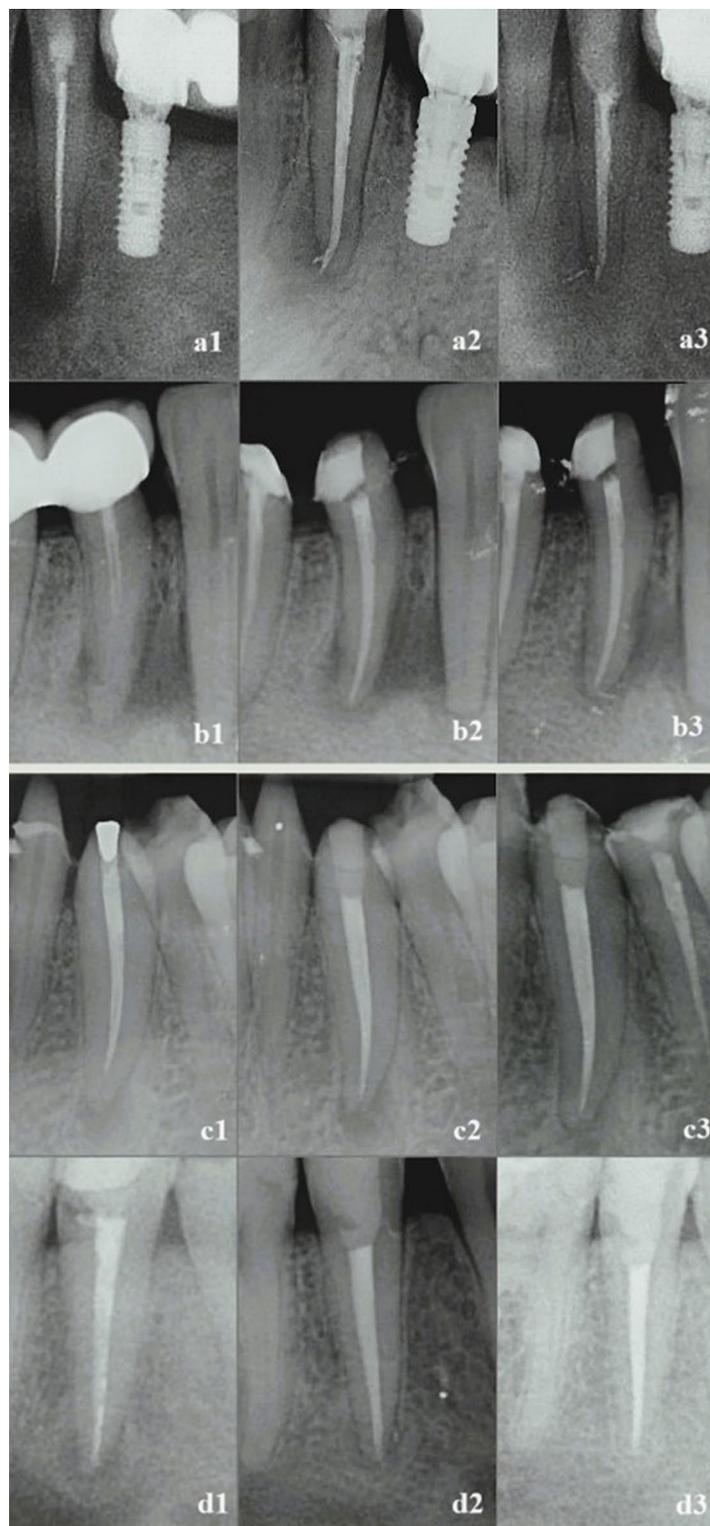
(a,b) Radiographic follow-up of periapical status before and after Re-RCT in HT patients; (a1) preoperative, (a2) postoperative, (a3) 12 months follow-up after Re-RCT, (b1) preoperative, (b2) postoperative, (b3) 7 months follow-up after Re-RCT. (c,d) Radiographic follow-up of periapical status before and after Re-RCT in healthy individuals (c,d) (c1) preoperative, (c2) postoperative, (c3) 12 months follow-up after Re-RCT, (d1) preoperative, (d2) postoperative, (d3) 18 months follow-up after Re-RCT.
